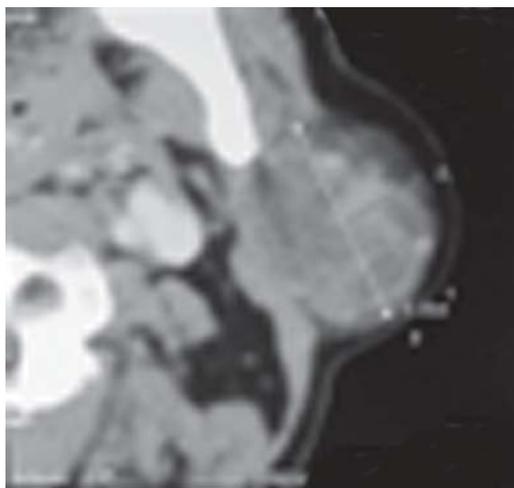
CT scan showing lump adjacent to parotid gland
